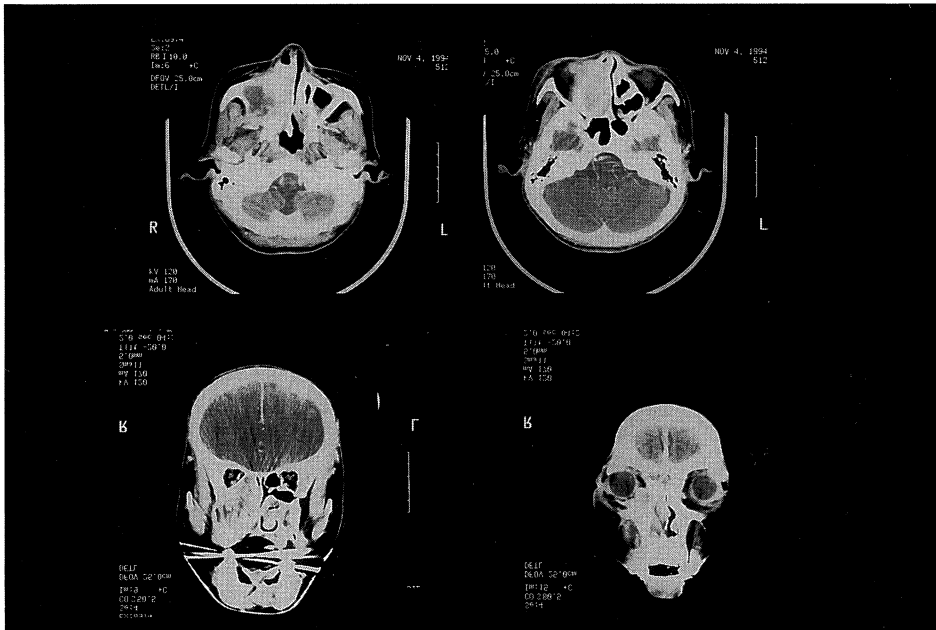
Enhanced computed tomographic scans showed a large mass in the right nasal cavity, maxillary sinus and ethmoid sinus. The tumor invaded the right orbit.
